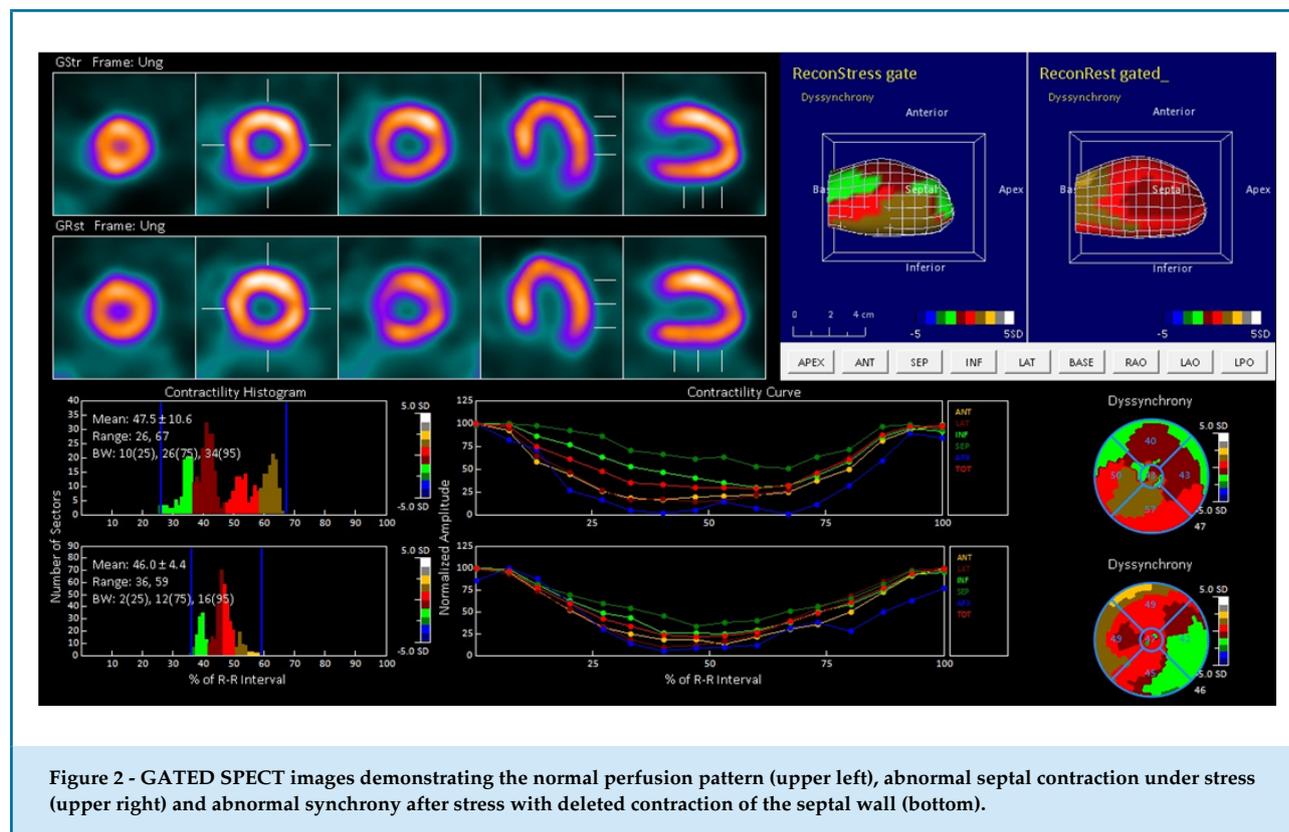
GATED SPECT images demonstrating the normal perfusion pattern (upper left), abnormal septal contraction under stress (upper right) and abnormal synchrony after stress with deleted contraction of the septal wall (bottom).
